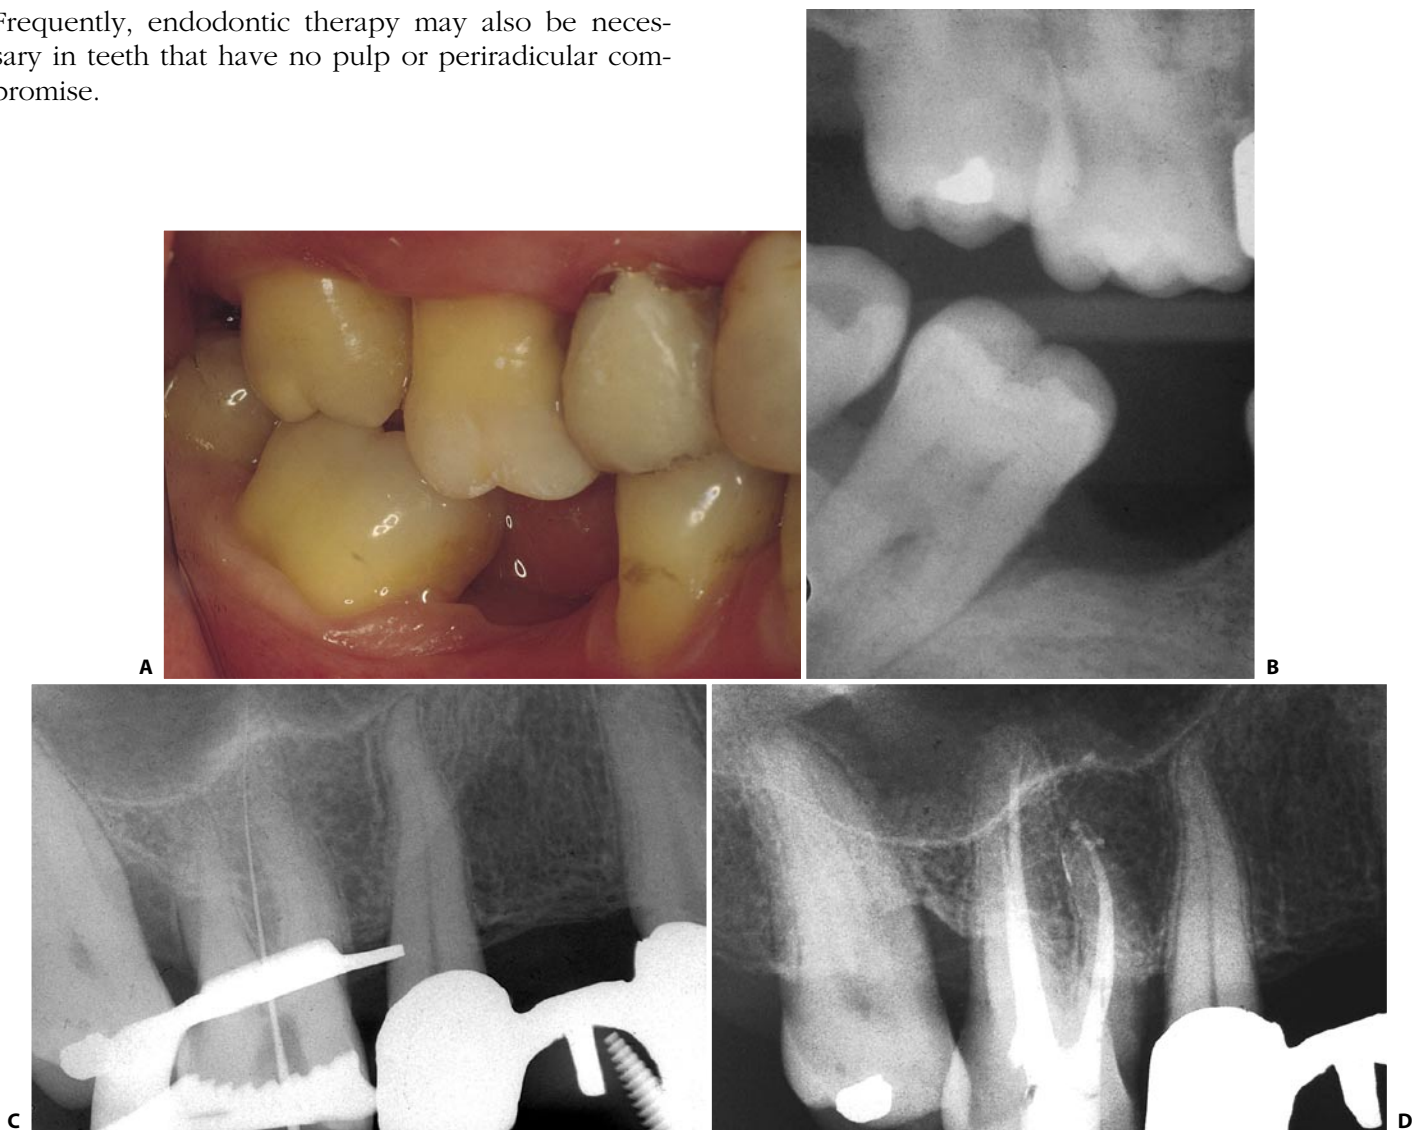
A. The maxillary first molar, because of its significant extrusion, must be treated endodontically before prosthetic treatment. B. Bitewing radiograph. C. Intraoperative radiograph. D. Postoperative radiograph.
